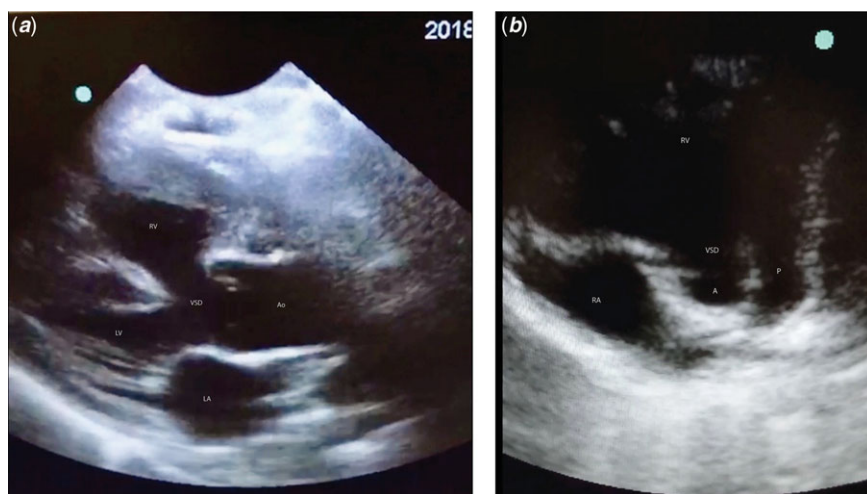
Images of Tetralogy of Fallot in a cyanosed 4-year-old child (a) shows the parasternal long axis view in Tetralogy of Fallot with the overriding aorta and sub-aortic ventricular septal defect. RV - right ventricle, LV - left ventricle, VSD - ventricular septal defect, Ao - aorta, LA - left atrium. The short axis image (b) shows the perimembranous ventricular septal defect and narrowed right ventricular outflow tract. RA - right atrium, RV - right ventricle, P - pulmonary valve/right ventricular outflow tract, A - aortic valve, VSD - ventricular septal defect.
